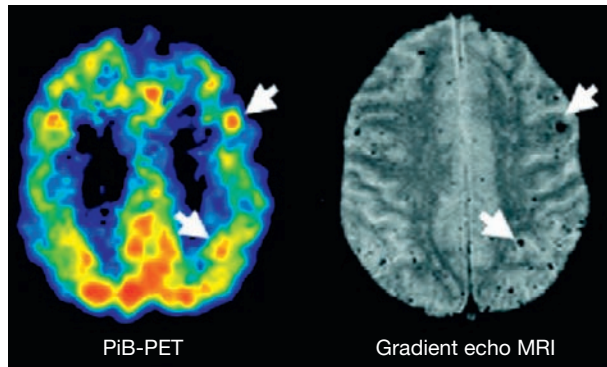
Amyloid deposition in CAA. Shown are transverse supraventricular Pittsburgh Compound B (PiB)-PET and coregistered gradient-echo MRI images from a patient with cerebral amyloid angiopathy. Microbleeds, seen as dark dots on MRI, at times appear close to foci of amyloid deposition on PiB-PET (arrows).
